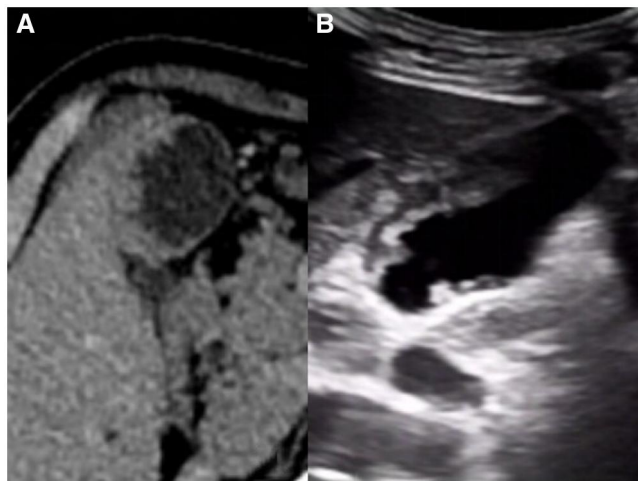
CT and US images of the case. (A) CT showed uneven thickening of the gallbladder wall with iso-density. Low-density fat tissue which separates the gallbladder wall from adjacent liver parenchyma was reserved. (B) US demonstrated the posterior wall of the gallbladder was not uniformly thickened with strong echo. The “comb—tooth” like appearance on both CT and US images was not so clear as on MRI images.
